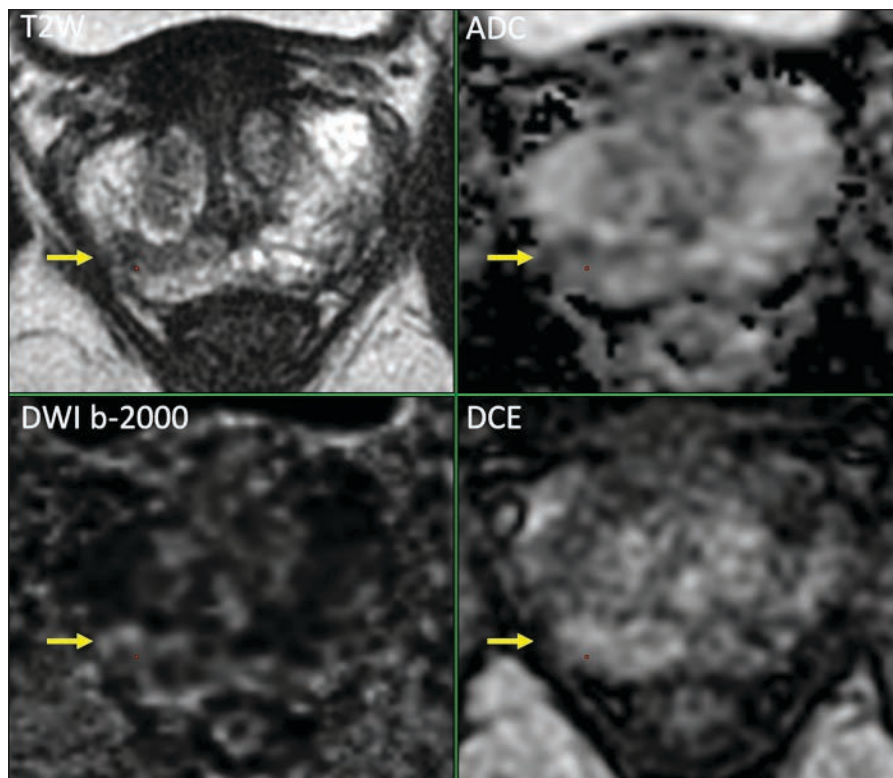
DCE-MRI adds value in indeterminate lesions with PI-RADS 3 scores in non-contrast MRI. 65 year-old man, cT1, PSA 3.5 ng/ml, PVMRI 45 ml, PSAD 0.08 ng/ml², primary diagnosis. Suspected lesion of 6 mm right peripheral zone with PI-RADS score 4 (upgraded 3+1) (T2W:3, DWI/ADC:3, DCE: +). This wedge-shaped lesion on T2W showed hardly any suspicious diffusion restriction on b-2000 (equivocal score 3), and a small focus with moderately decreased signal intensity on ADC. DCE showed a larger region of focal enhancement (+), and supported the equivocal score 3 of DWI/ADC, upgrading to a final PI-RADS score 4, indicating targeted biopsy. Three MRI-directed fusion biopsies revealed Gleason score 3+3=6 (ISUP grade 1) without cribriform / intraductal growth, in all three biopsies.
